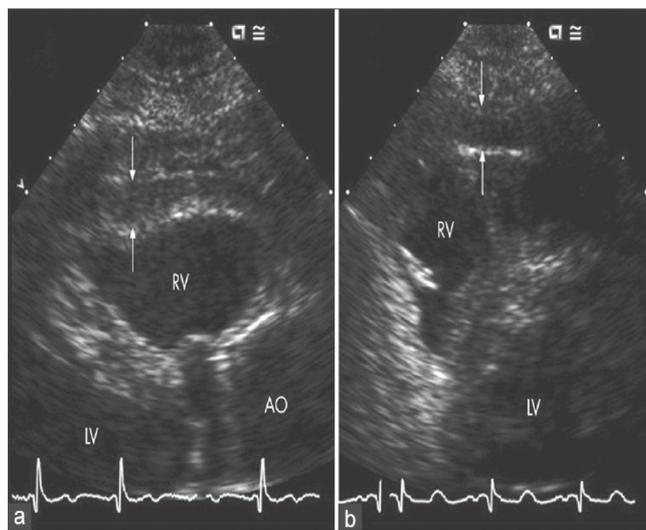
Measurement of EEATT with Echocardiography (Echo free space indicated).
